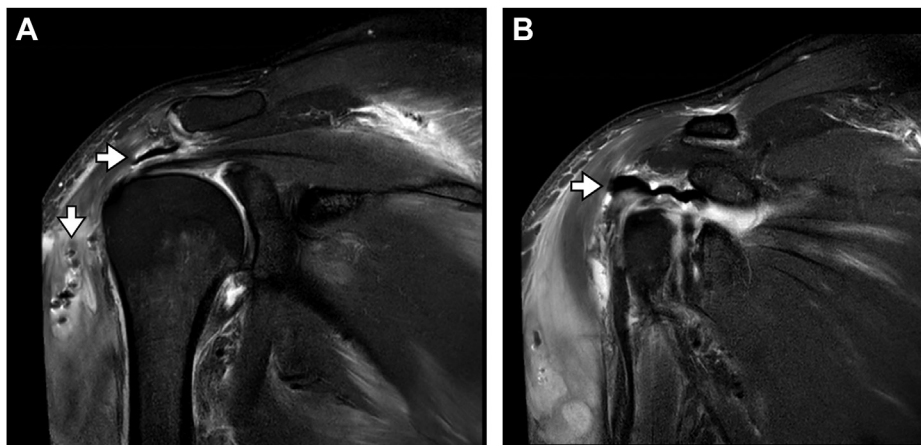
(A and B) Coronal oblique fat-suppressed MRI right shoulder. Gas within soft tissue and extensive edema of the subcutaneous and intramuscular fat is observed.
